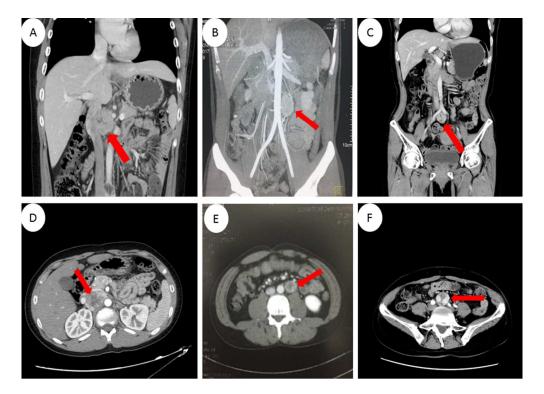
Abdominal CT or MRI scans of the probands. (A and D) Coronal (A) and axial (D) CT images of the 5.1×3.4 cm retroperitoneal mass between the aorta and inferior vena cava in proband 1; (B and E) Coronal (B) and axial MRI (E) images of the $3 \times 2 \times 2$ cm retroperitoneal para-aorta mass in proband 2; (C and F) Coronal (C) and axial (F) images of the 2.9×2.7 cm mass located at the bifurcation of the abdominal aorta in proband 3.
